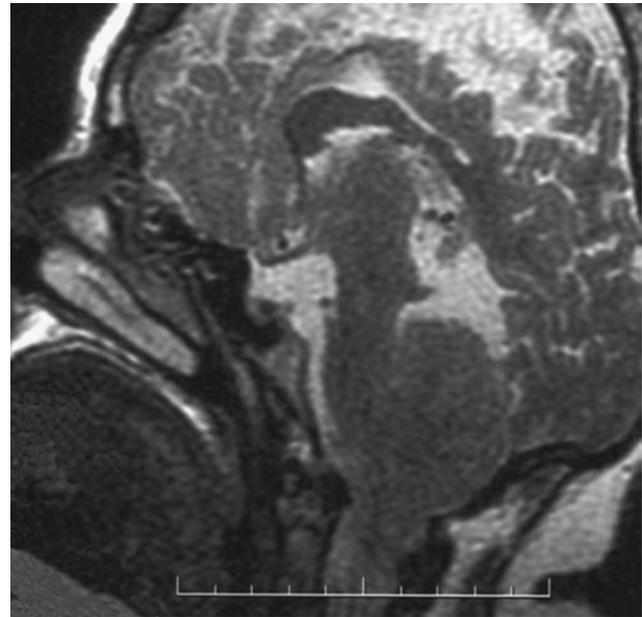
Vermian herniation in the Chiari 2 malformation as demonstrated on a sagittal magnetic resonance image.
